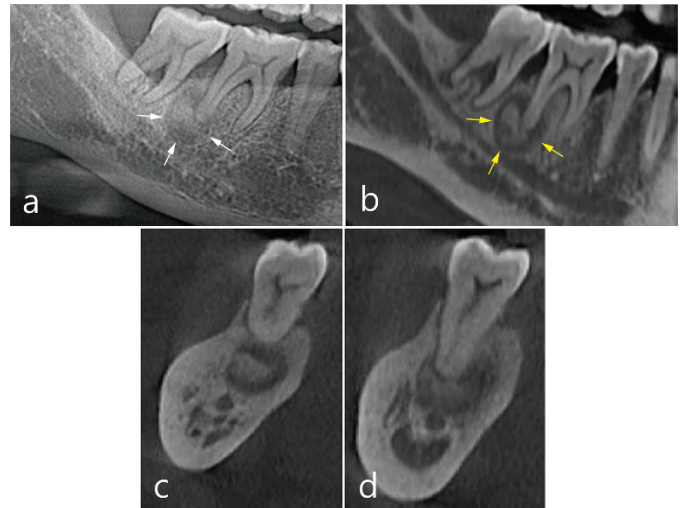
(a) A radiolucent periapical lesion was observed in the distal root of tooth #30 on a preoperative panoramic radiography; (b) In the sagittal image of CBCT, unilocular mixed radiolucent and radiopaque image with well-defined border was observed within the lesions. The lesion extended to the upper part of the mandibular canal; (c, d) In the coronal image of CBCT, a calcified mass was surrounded with radiolucent rim. Radiologically, the periapical lesion was suggested to be focal cemento-osseous dysplasia (FCOD).
